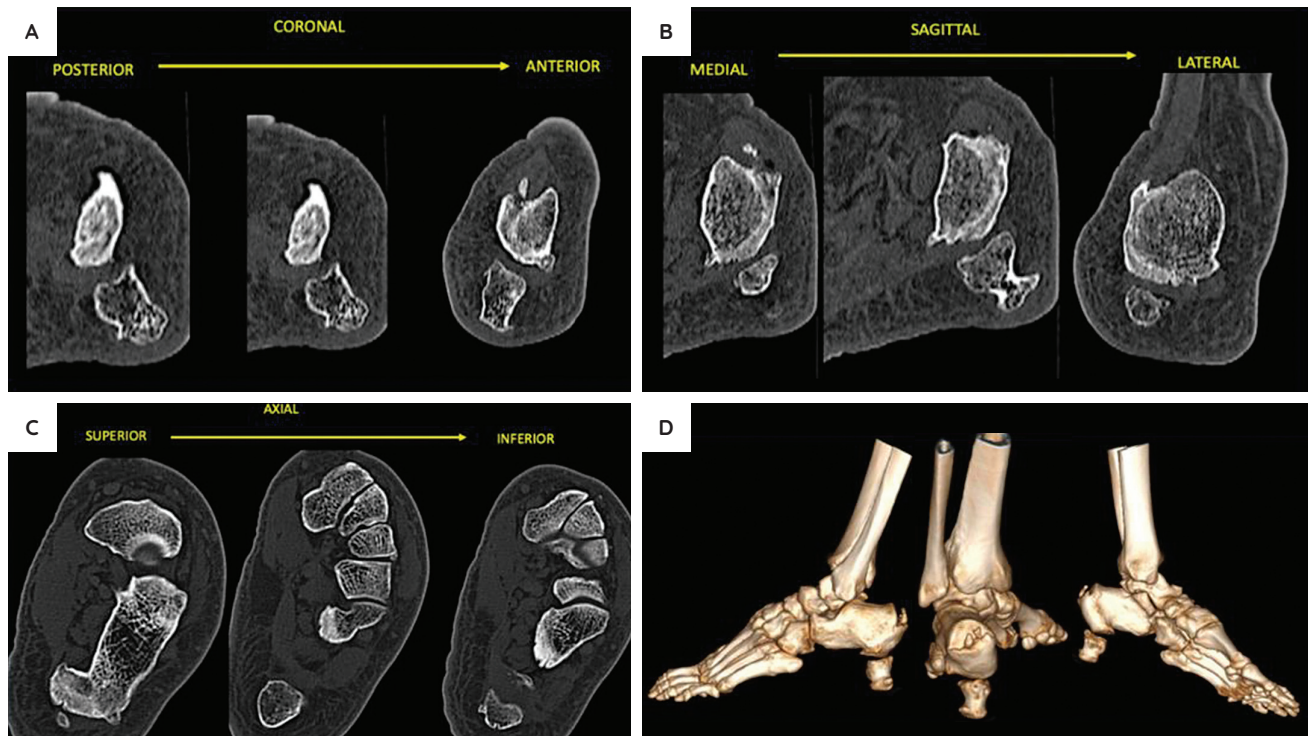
Diagnostic computed tomography scan of the patient's left foot showing coronal plane cuts from posterior to anterior (A), axial plane cuts from superior to inferior (B), sagittal plane cuts from medial to lateral (C), and 3D reconstruction of the foot (D).
